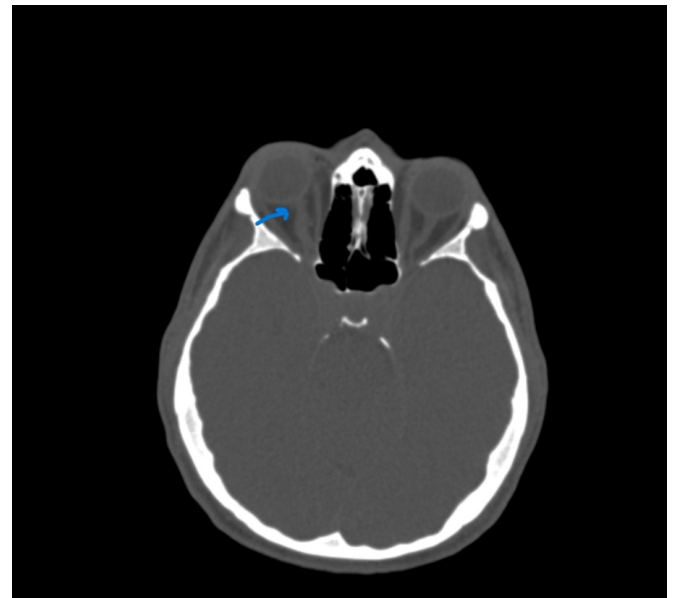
Axial computed tomography scan showed an intact right globe with anterior displacement and disruption of optic nerve at the attachment to globe (blue arrow).
